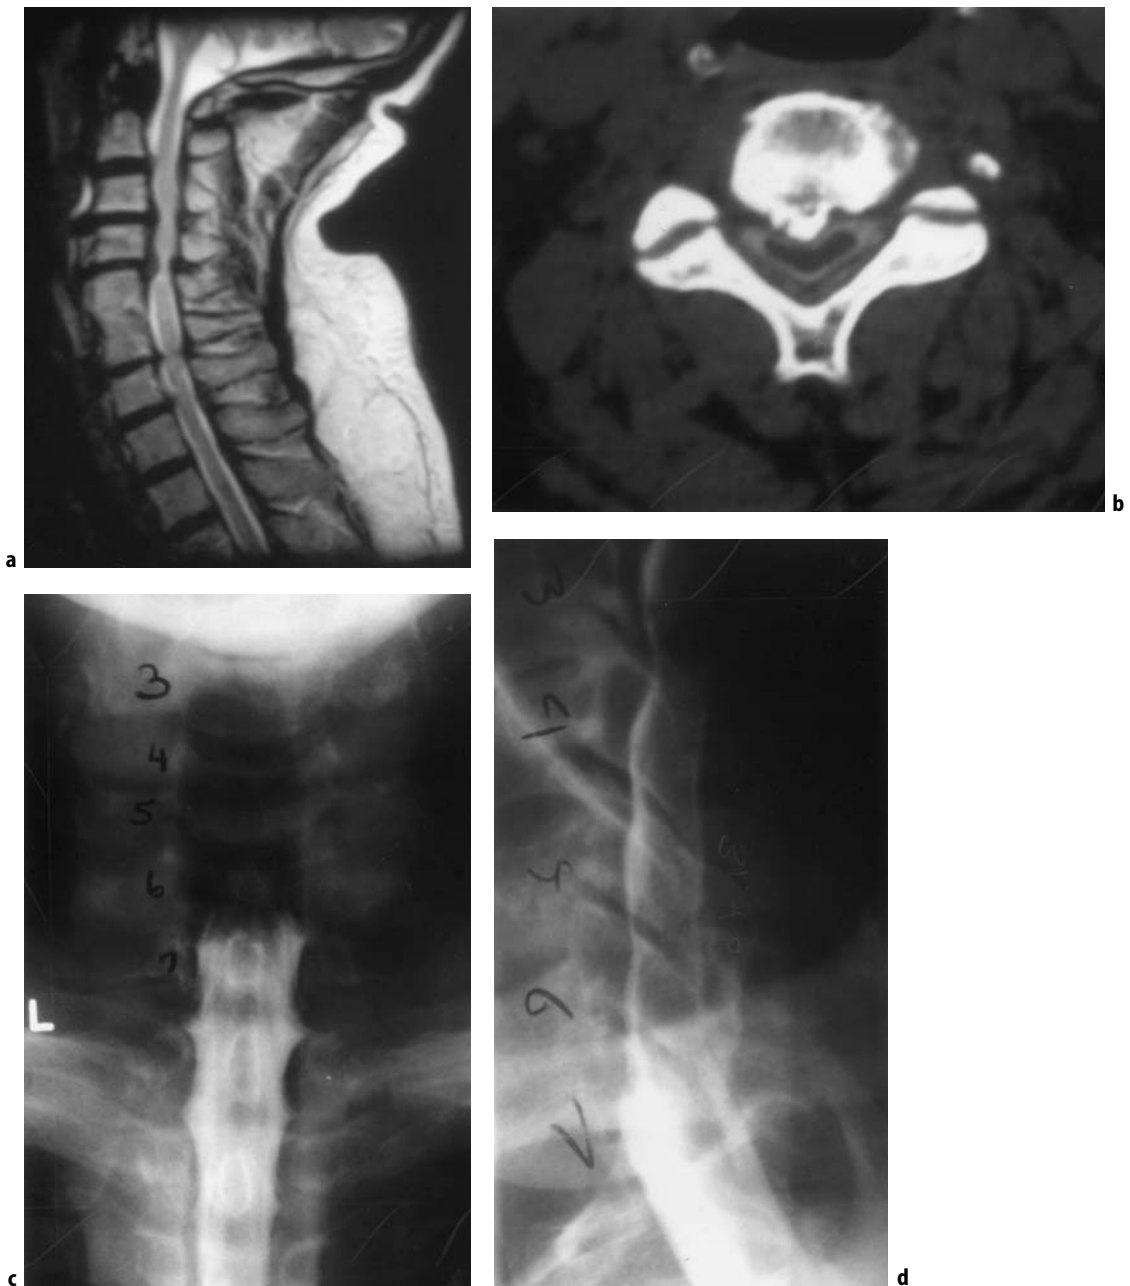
Cervical spondylotic myelopathy. There are three potential mechanisms of compressive myelopathy and spondylosis: AP diameter stenosis a, anterior spinal cord encroachment b and dynamic compression (c and d). a Lateral cervical spine MRI study demonstrating narrowing of the spinal canal from C3 to C5, due to congenital narrowing of the canal compounded by bulging disk and osteophytes at the interspaces. b Post-myelogram CT scan axial view, demonstrating an anterior osteophyte indenting and deforming the anterior aspect of the spinal cord. (c and d) An AP X-ray demonstrates a complete block at the C6–C7 level c. With the head flexed, the dye passes across the level of the obstruction to the upper cervical spine, and there is no focus of compression seen in this image d.
